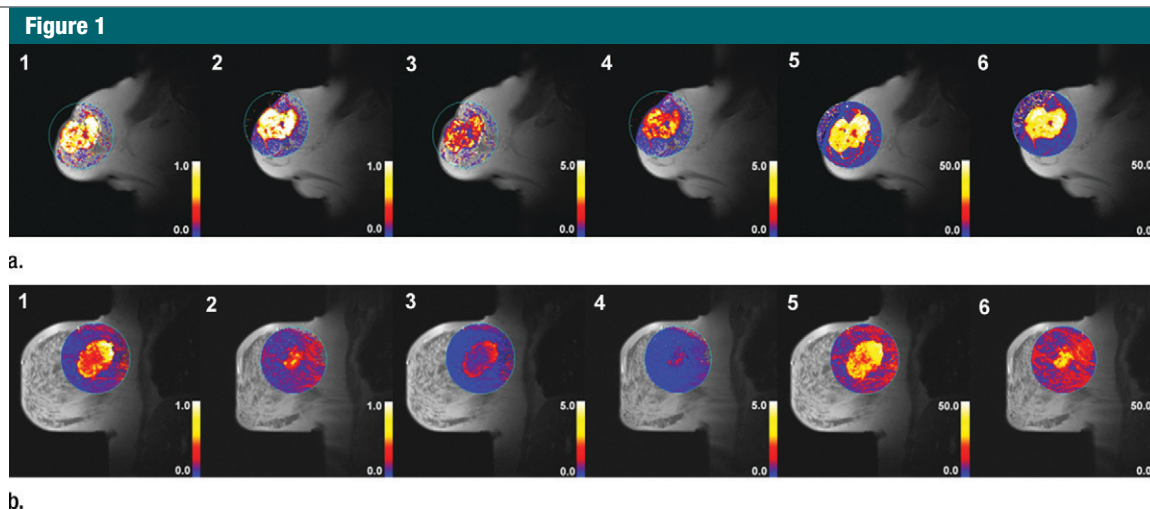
(a) Dynamic T1-weighted MR images of a 60-mm grade 2 breast carcinoma in the right breast (T3 N0 M0, estrogen receptor positive, progesterone receptor positive, HER2 negative) of a 70-year-old woman whose disease relapsed distally 38.8 months after diagnosis. The patient died 47.2 months after initial radical treatment. Her tumor displayed high values for K^{trans} , k_{ep} , and $IAUGC_{60}$ after two cycles of NAC. 1, K^{trans} before treatment (median, 0.403 minute^{-1}), 2, K^{trans} after treatment (median, 0.603 minute^{-1}), 3, k_{ep} before treatment (median, 1.212 minutes^{-1}), 4, k_{ep} after treatment (median, 1.816 minutes^{-1}), 5, $IAUGC_{60}$ before treatment (median, 19.49 mmol/sec), and, 6, $IAUGC_{60}$ after treatment (median, 23.41 mmol/sec). (b) Dynamic T1-weighted MR images of a 57-mm grade 2 breast carcinoma in the right breast (T3 N0 M0, estrogen receptor negative, progesterone receptor positive, HER2 negative) of a 61-year-old woman who had no evidence of disease recurrence more than 5 years after diagnosis. The patient was still alive at the time this manuscript was written. Tumor displayed lower values for K^{trans} , k_{ep} , and $IAUGC_{60}$ after treatment. 1, K^{trans} before treatment (median, 0.271 minute^{-1}), 2, K^{trans} after treatment (median, 0.146 minute^{-1}), 3, k_{ep} before treatment (median, 0.708 minute^{-1}), 4, k_{ep} after treatment (median, 0.403 minute^{-1}), 5, $IAUGC_{60}$ before treatment (median, 16.47 mmol/sec), and 6, $IAUGC_{60}$ after treatment (median, 12.19 mmol/sec).
